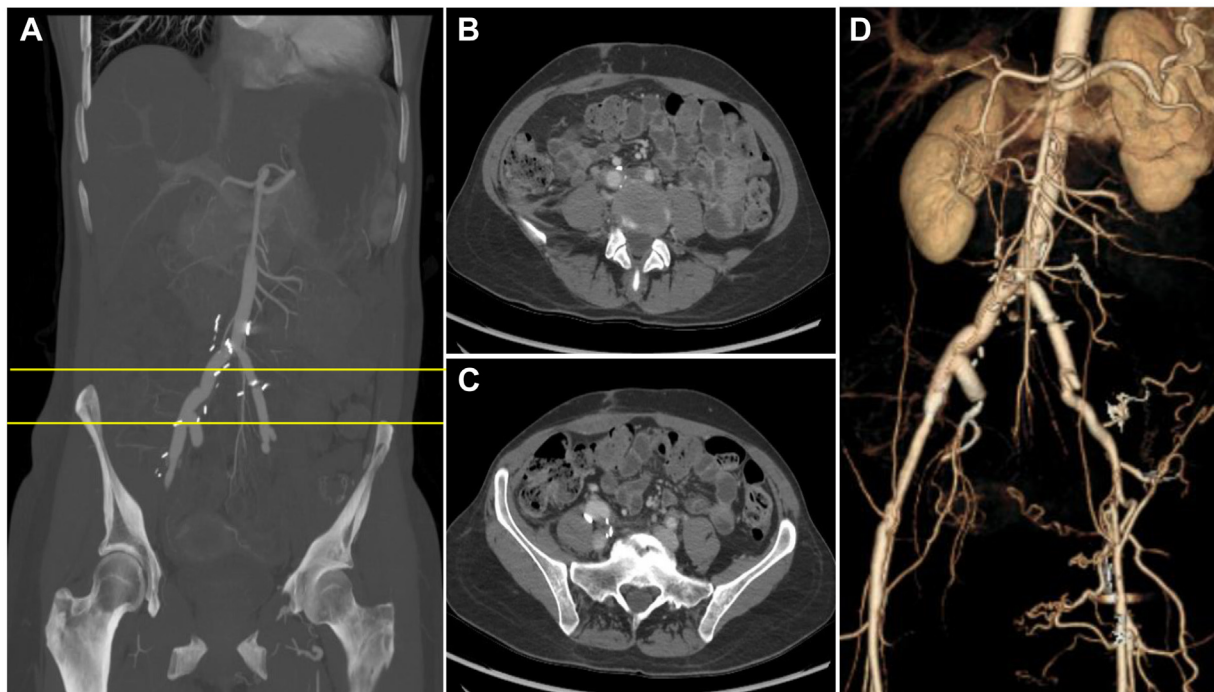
Computed tomography angiography (CTA) including three-dimensional reconstruction of the patient 11 months postoperatively. A, Coronal images showing stability of bilateral repairs and resolution of large retroperitoneal hematoma. *Yellow lines* indicate level of axial image slices in superior (B) and inferior (C) views. D, Three-dimensional reconstruction of final postoperative imaging.
